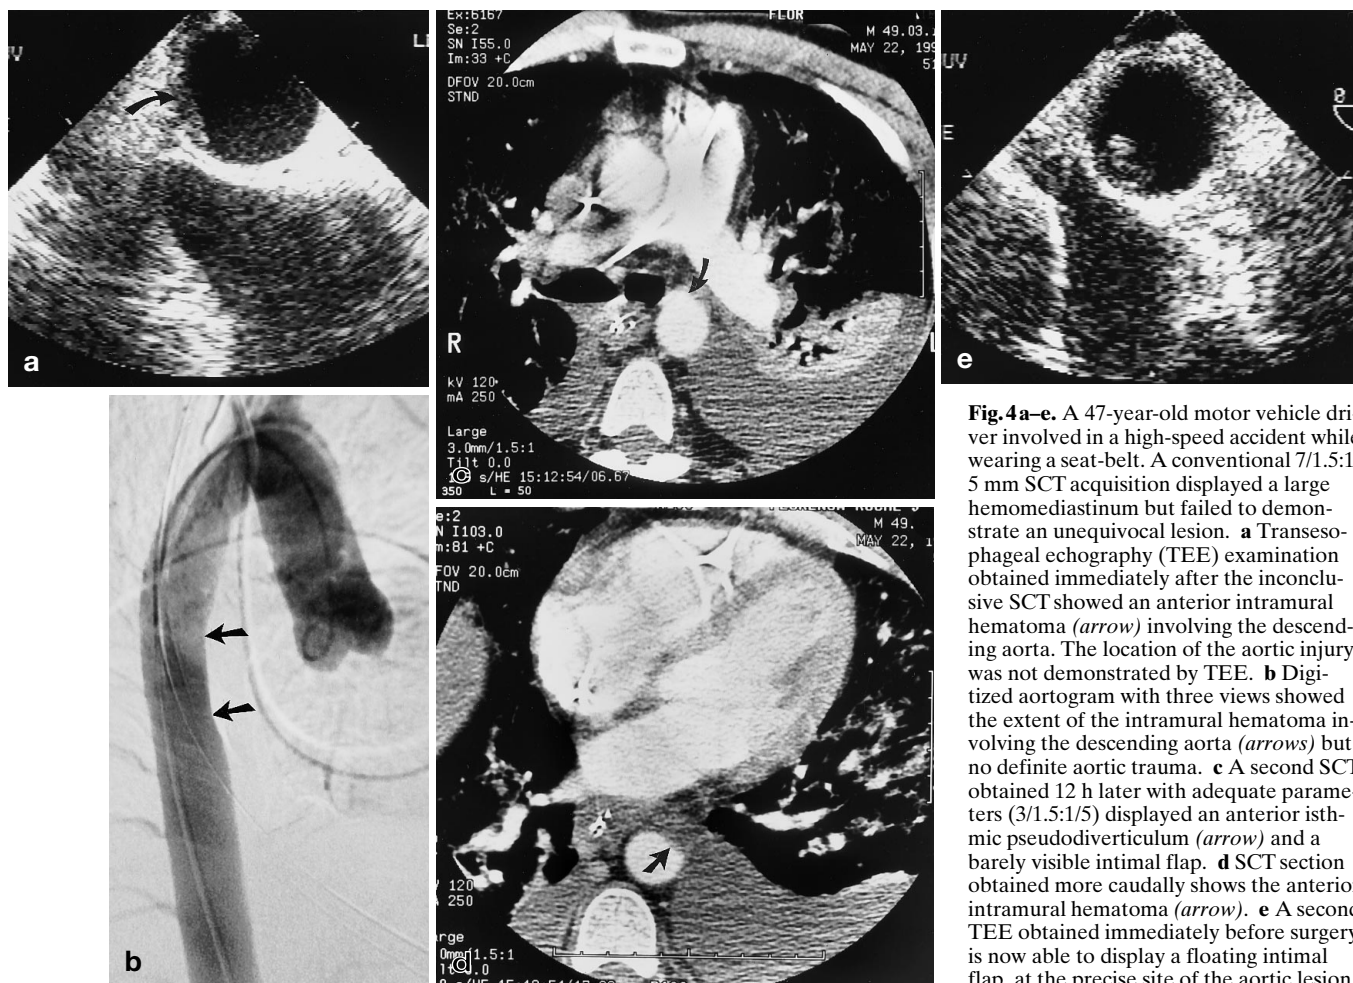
A 47-year-old motor vehicle driver involved in a high-speed accident while wearing a seat-belt. A conventional 7/1.5:1/5 mm SCT acquisition displayed a large hemomediastinum but failed to demonstrate an unequivocal lesion. a Transesophageal echography (TEE) examination obtained immediately after the inconclusive SCT showed an anterior intramural hematoma (arrow) involving the descending aorta. The location of the aortic injury was not demonstrated by TEE. b Digitized aortogram with three views showed the extent of the intramural hematoma involving the descending aorta (arrows) but no definite aortic trauma. c A second SCT obtained 12 h later with adequate parameters (3/1.5:1/5) displayed an anterior isthmic pseudodiverticulum (arrow) and a barely visible intimal flap. d SCT section obtained more caudally shows the anterior intramural hematoma (arrow). e A second TEE obtained immediately before surgery is now able to display a floating intimal flap, at the precise site of the aortic lesion
